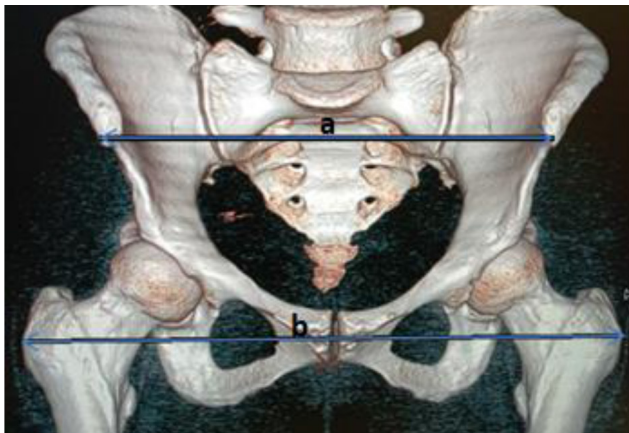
Measurements of the AISD (a), and the BTD (b). A reconstructed CT scanned image obtained from the Sodo Christian Hospital's PACS, 2020.
